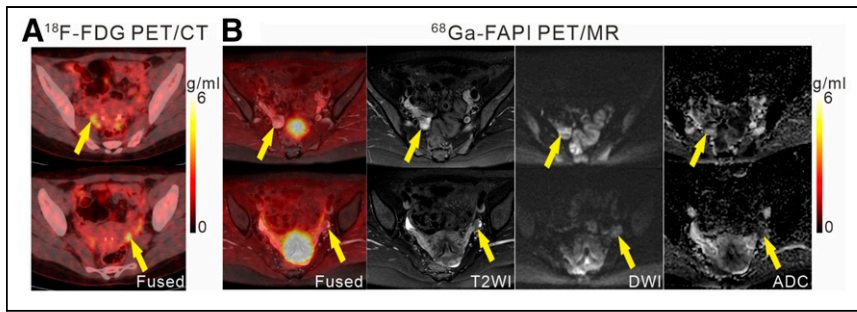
Corpus luteum as false-positive on ^{18}F -FDG PET/CT and ^{68}Ga -FAPI PET/MR in a 35-year-old woman (patient 12). Two foci of increased ^{18}F -FDG activity (A, arrows, $\text{SUV}_{\text{max}} = 5.0$ [right], 5.7 [left]) and ^{68}Ga -FAPI activity (B, arrows, $\text{SUV}_{\text{max}} = 4.3$ [right], 3.3 [left]) were observed in ovaries, but without obvious abnormal morphology and signal changes on MR images (B). Operative exploration confirmed these “lesions” as corpus luteum. ADC = apparent diffusion coefficient.
